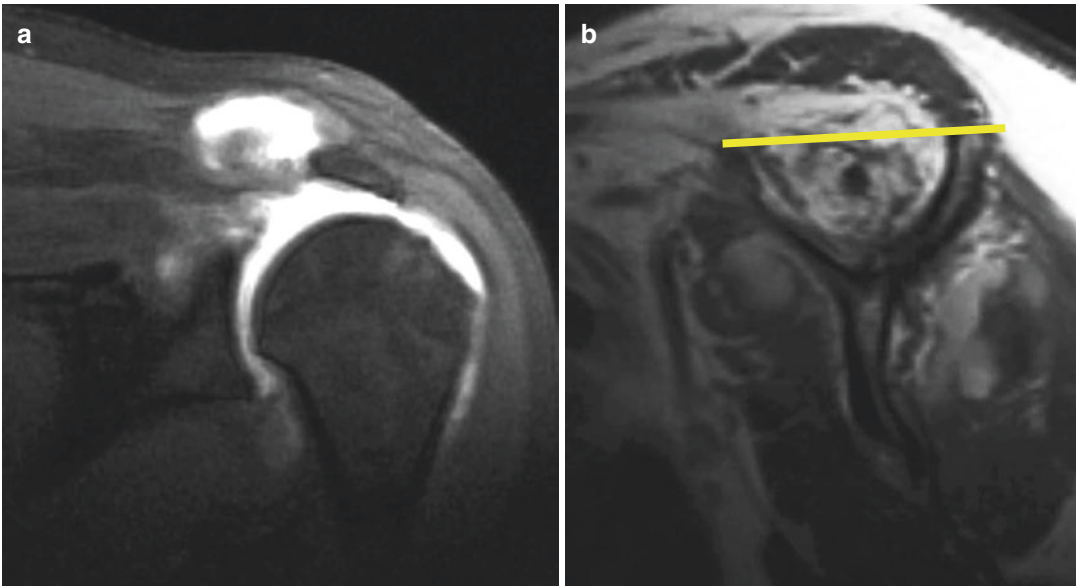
(a, b) Grading of fatty changes within the supraspinatus muscle associated with a rotator cuff tear. (a) Coronal fat-suppressed T1-weighted MR arthrogram showing a full-thickness tear of the supraspinatus. (b)
